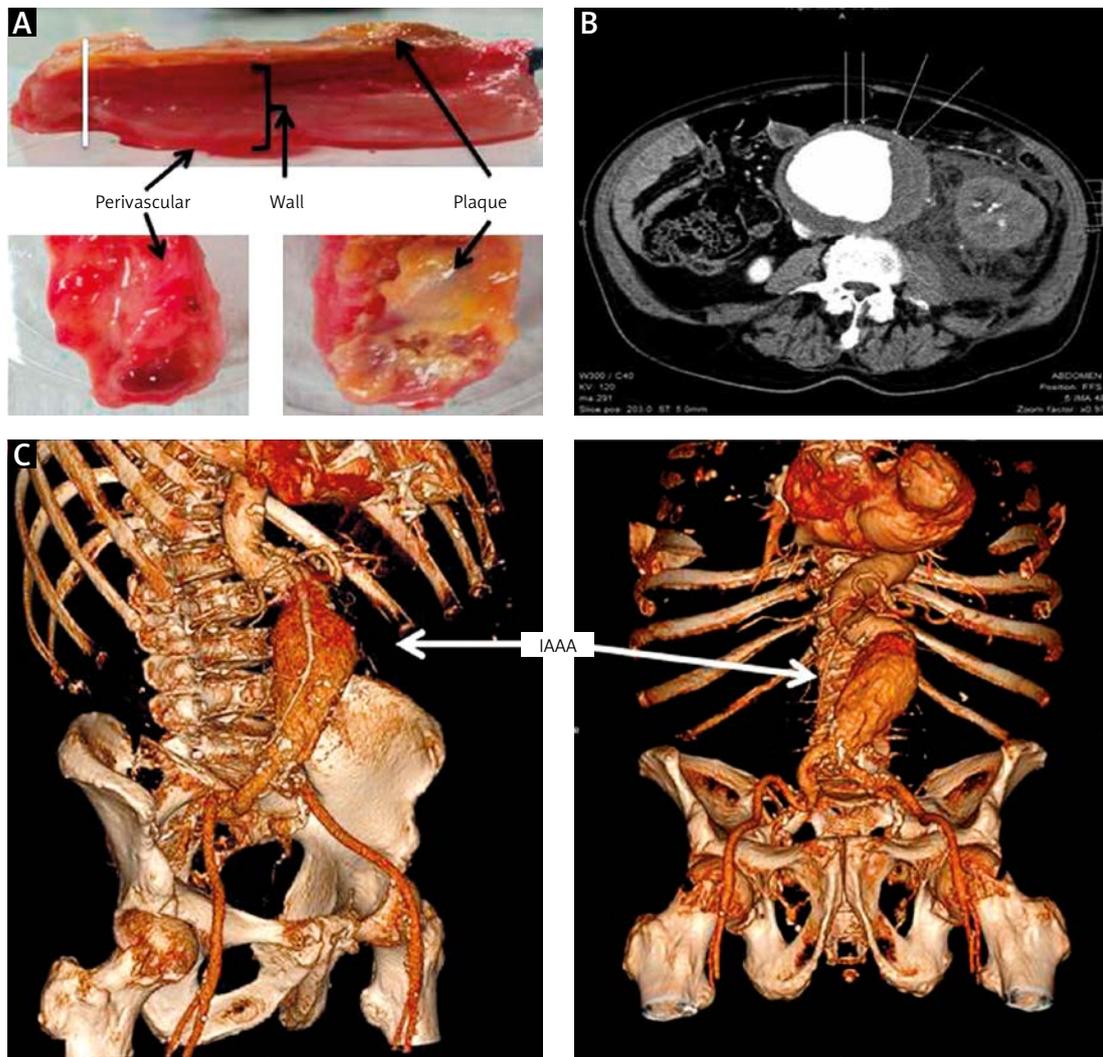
A – IAAA wall in the context of perivascular tissues and atherosclerotic plaque. The size bar indicates 15 mm. B – Angio-CT image showing an abdominal aorta aneurysm. Arrows mark lines showing the thickened and inflamed wall of the abdominal aorta. C – 3D reconstruction of IAAA (white arrows)
